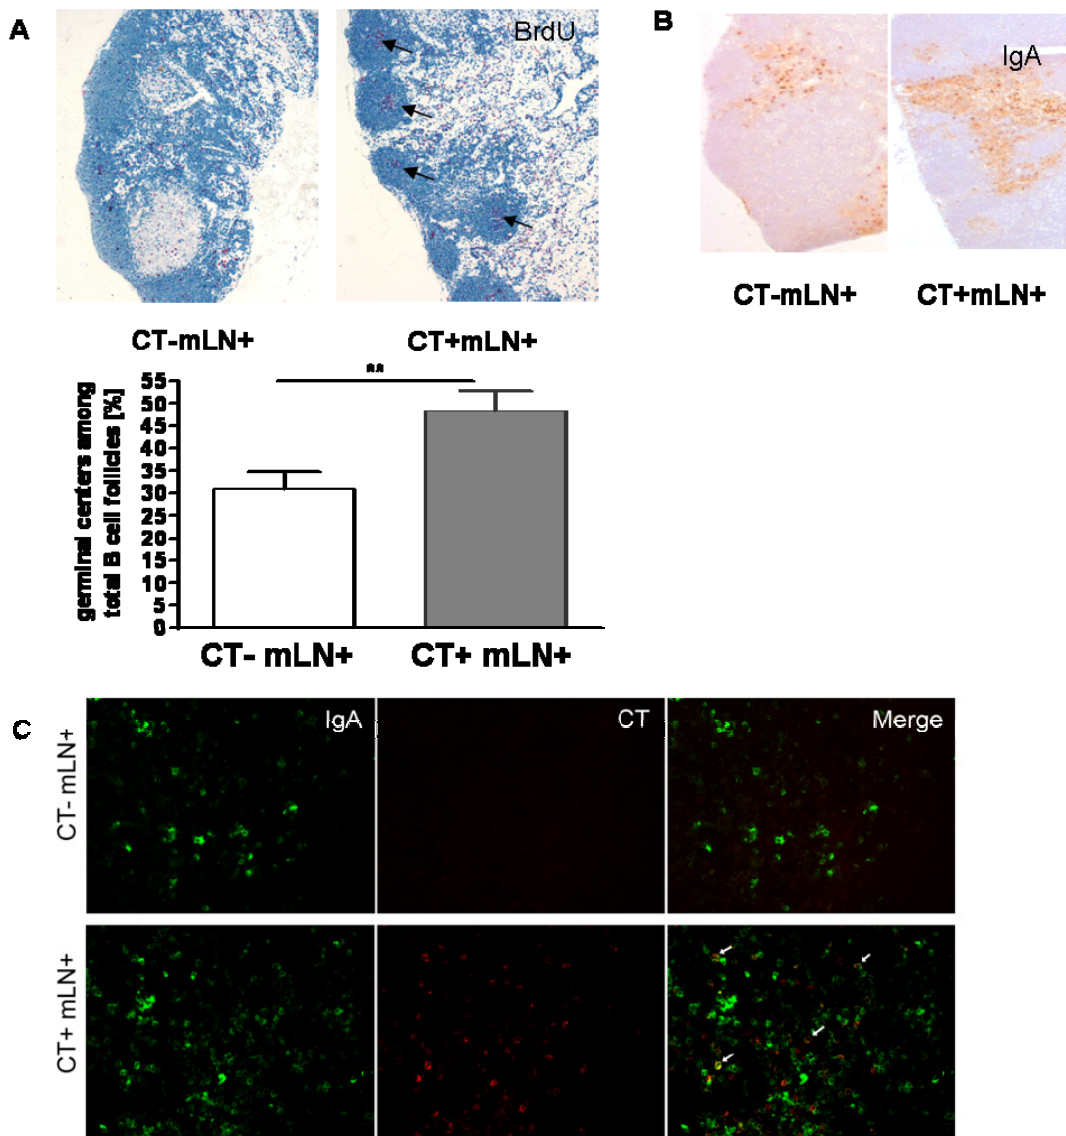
CT administration leads to an increase of secondary follicles and induces higher numbers of germinal centres and IgA in the mLN
